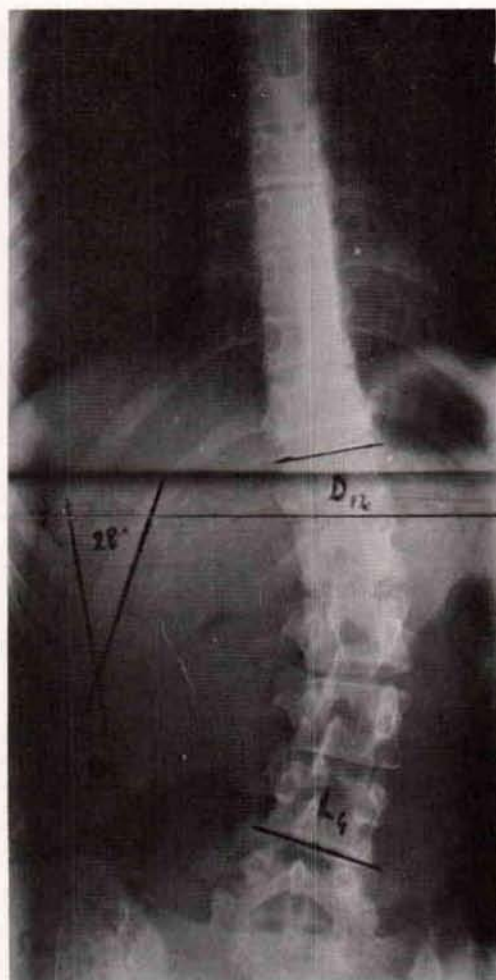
X-ray of the spine in a 13-year-old girl with right dorsolumbar scoliotic curve of 28 degrees.
